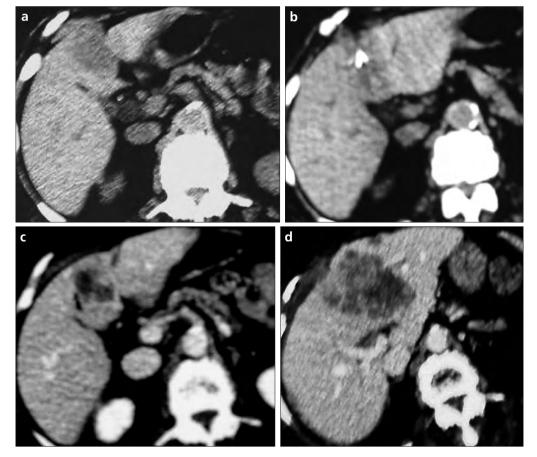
a-d. CT images of a 61-year-old man with a liver metastasis (in segment IV) of adenocarcinoma type. The lesion was treated by radiofrequency ablation (RFA) (a, b). Needle electrode insertion lines are visible (b). Dynamic CT scan obtained after RFA (c) shows a coagulated lesion with the hypervascular ring enhancement. The 1- month follow-up CT-scan revealed residual enhancement, due to lesion recurrence and a second RFA was performed (not shown here). Six months later, follow-up CT-scan (d) shows a larger mass near the ablated area, representing lesion recurrence, and a new subcapsular lesion.
